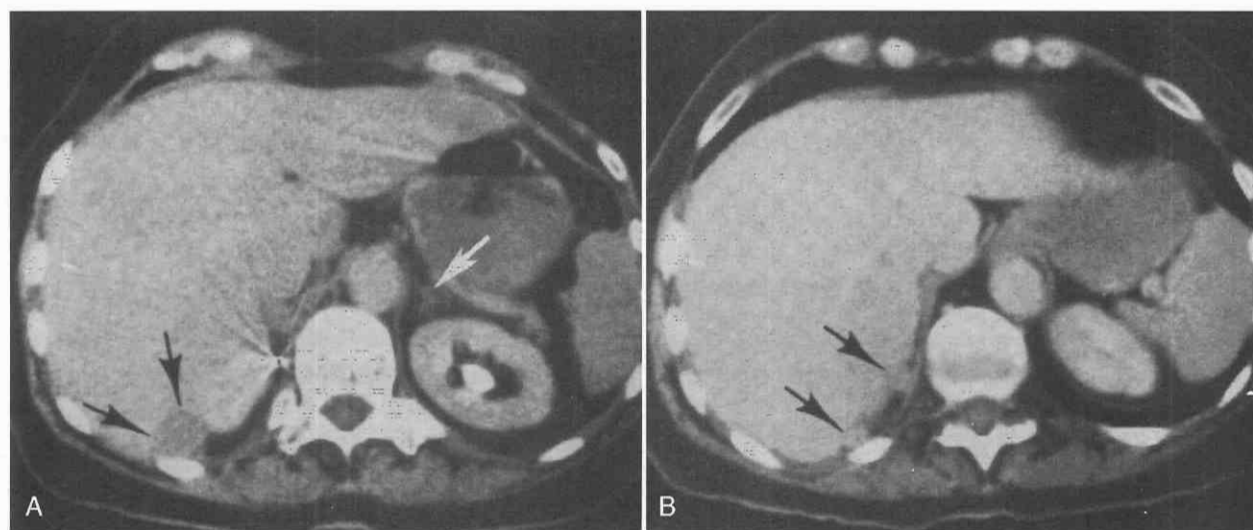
Recurrent pheochromocytoma. CT was performed to evaluate the left adrenal gland in a patient with biochemical evidence of a recurrent pheochromocytoma. The original tumor had been removed several years previously. *A*, CT scan at one level shows normal left adrenal gland (white arrow) but also reveals a low-density mass, 1.5 cm in diameter, in the operative site (black arrows). *B*, CT scan at a slightly higher level shows two additional nodules (arrows) between the right lobe of the liver and the diaphragm. At surgery, these were found to be three nodules of pheochromocytoma "rests."
